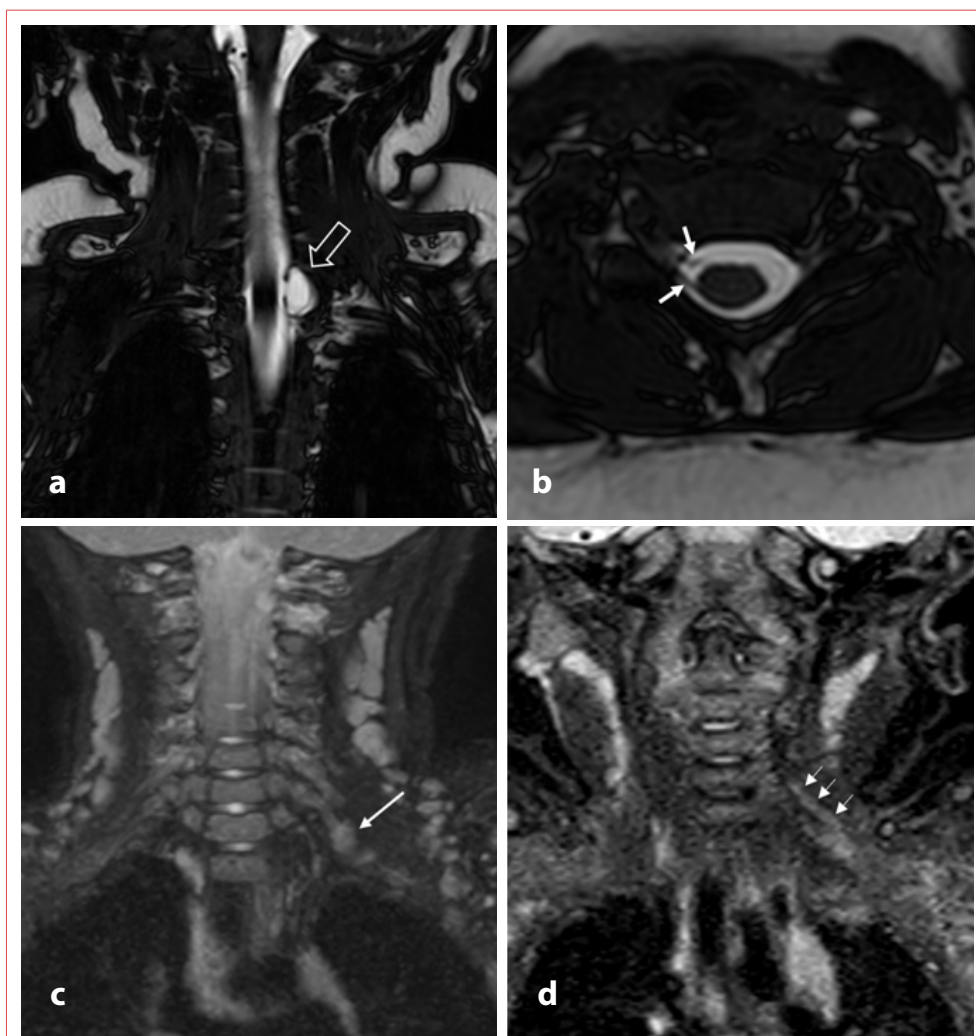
Representative magnetic resonance imaging findings of preganglionic and postganglionic injury in obstetric brachial plexus palsy. Coronal (a) and axial (b) heavily T2-weighted images demonstrate a left C7 pseudomeningocele (open arrow) and associated root avulsion, representing preganglionic injury. Normal dorsal and ventral nerve rootlets are shown on the contralateral side (white arrows). Coronal short TI inversion recovery (STIR) maximum intensity projection image (c) and coronal STIR image (d) demonstrate postganglionic abnormalities, including neuroma-like nodular thickening (long arrow) and asymmetric thickening with increased signal intensity of the left C5 and C6 roots at the interscalene level (short arrows).
